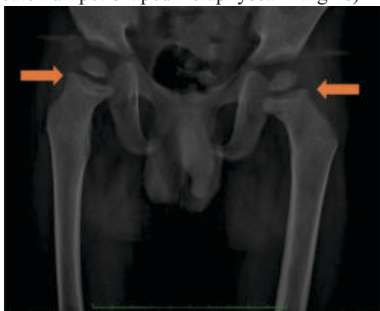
Anteroposterior radiograph of the pelvis and proximal
